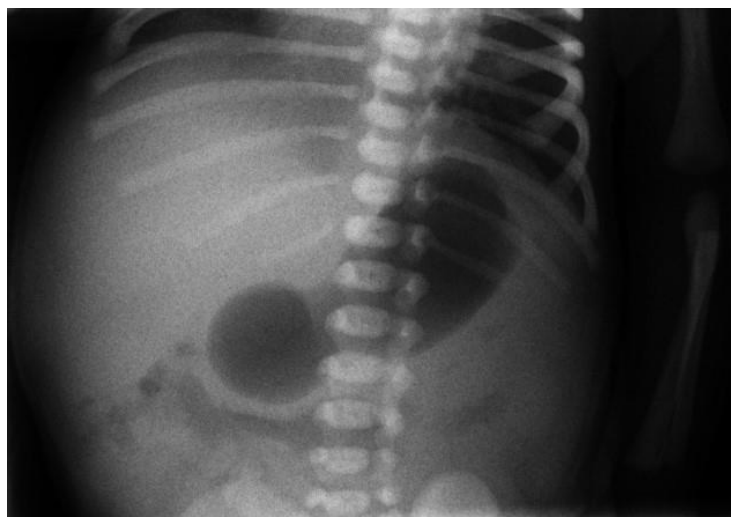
Abdominal radiography in the 3rd day of life is suspected to double bubble sign.
